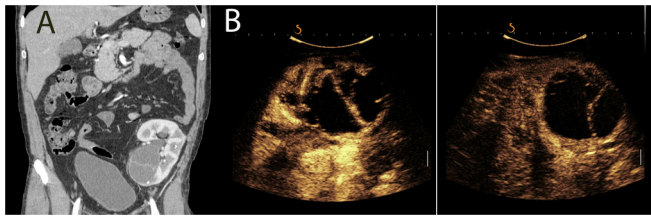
A – Preoperative venous phase CT scan, B – CEUS findings.
